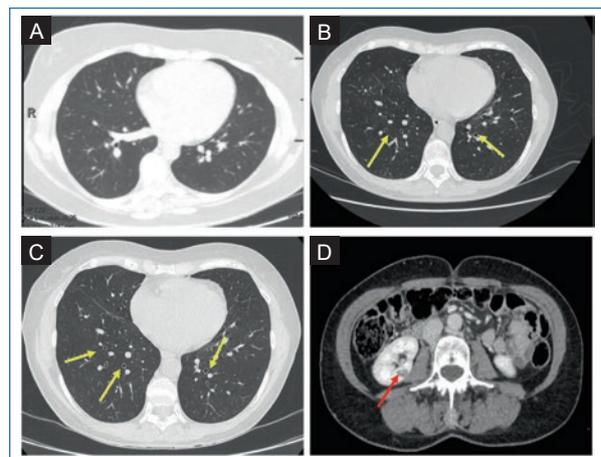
A: computed tomography (CT) scan performed 1 year before. It shows normal pleuropulmonary and airway structures. B-C: chest CT scan performed 2 years later. Several cystic lesions are observed within the lung parenchyma, a few millimeters in size, predominantly bilobar (yellow arrow). D: hypodense lesion in the lower pole of the right kidney (red arrow).
